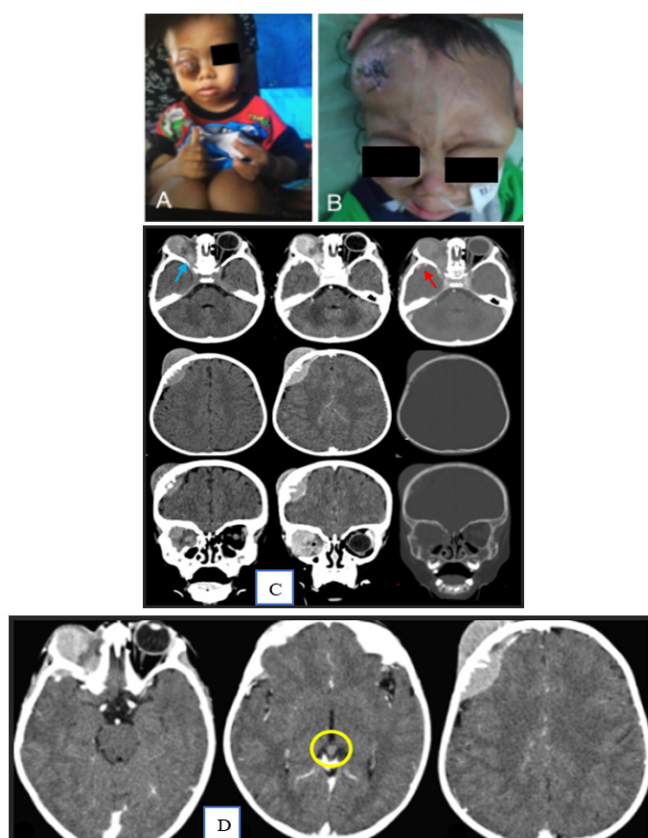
(A) Swelling of the right eye for the past 4 months, followed by (B) the extension of a mass to the right frontoparietal region. (C) Computed tomography (CT) of the head with axial and coronal contrast revealed a mass in the right frontoparietal region, which also extended to the right optic nerve (blue arrow) and the lateral wall of the orbit (red arrow). Additionally, there was erosion and a hair-on-end periosteal reaction in the adjacent bone, as well as involvement of the meninges and soft tissues. (D) Enlargement of the pineal gland with contrast enhancement (yellow circle)
